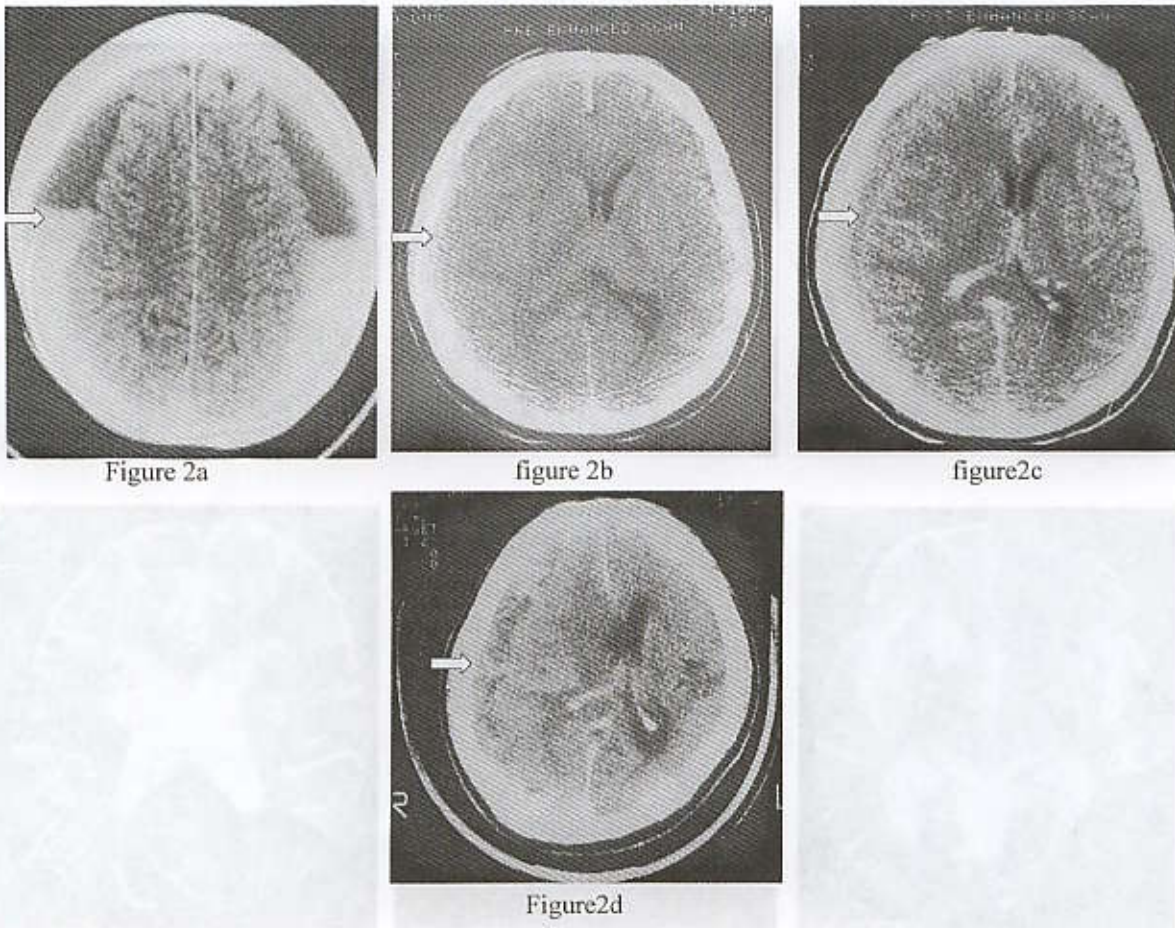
Axial CT brain scan of a patient with acute subdural hematoma (Figure 2a) appears as crescentic shape of hyperdensity of acute blood clot. Figure 2b shows isodensity of the hematoma on the right side which is hardly seen in pre-contrast study but is well demonstrated on the post-contrast study as in figure 2c. Figure 2d demonstrates lysis of blood clot in chronic subdural hematoma. A contrast study is helpful in subacute subdural hematoma.
